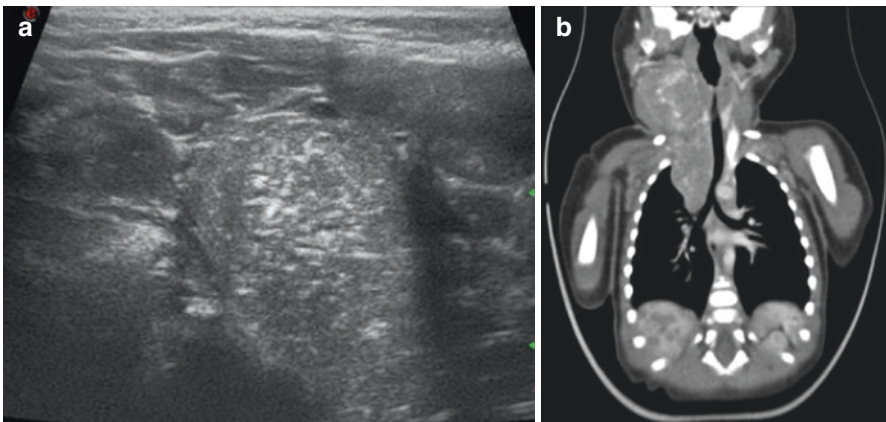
An 18-month-old boy with cervicothoracic neuroblastoma. Ultrasonography showed a solid cervical mass with sharp margins and scattered calcifications. The common carotid artery and internal jugular vein were not seen (a). On contrast-enhanced CT, coronal image (b) showed a large right-sided thoracic mass extending from the postero-superior mediastinum to the neck
